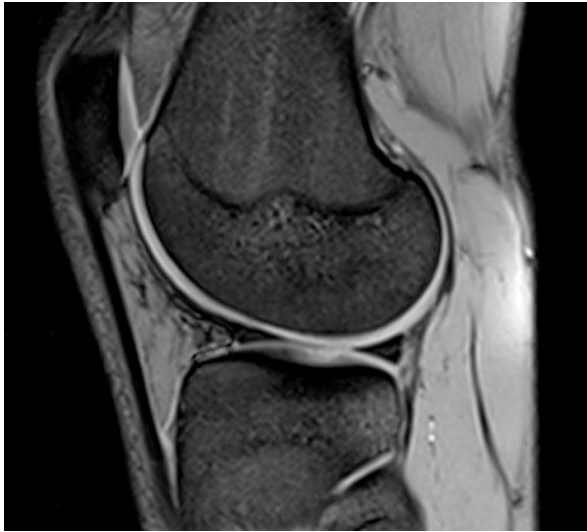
The ML appearance in MRI is normal
